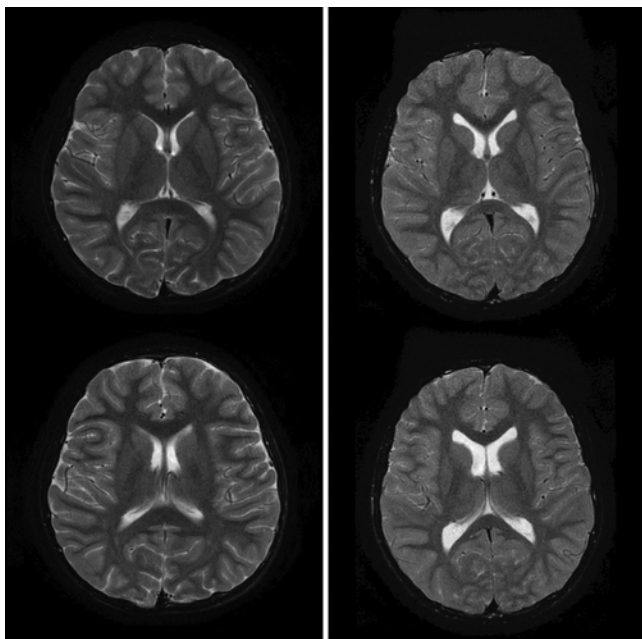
Axial T2-weighted MR images obtained in two 9-year-old boys without hydrocephalus, showing normal variation in ventricular dilation and volume 13.5 mL (left) and 37.3 mL (right).
